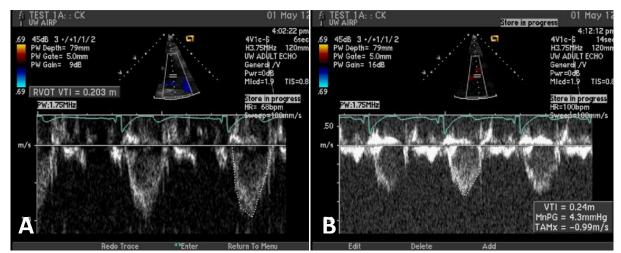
Ultrasound images at rest (A) and at 100 bpm (B), VTI increased from 20.3 cm to 24.0 cm.
